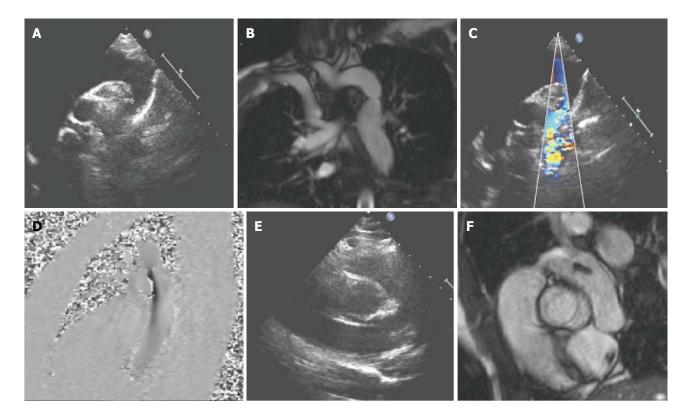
A 17-year-old girl with coarctation of the descending aorta, imaged by transthoracic echocardiography (A,C,E) and cardiovascular magnetic resonance (B,D,F). Imaging of the aortic arch using TTE can be challenging, depending on the suprasternal image quality A and especially in older children with poorer acoustic windows. CMR allows accurate measurement of the dimensions of the area of stenosis B and assessment of the remainder of the thoracic aorta and head and neck vessels. Flow velocity mapping D, similar to Doppler echocardiography C is used to measure peak velocity through the stenosed area and assess for a diastolic tail. In this case, the bicuspid aortic valve was not well visualised on TTE E but was clearly seen on CMR F. CMR: Cardiovascular magnetic resonance; TTE: Transthoracic echocardiography.
